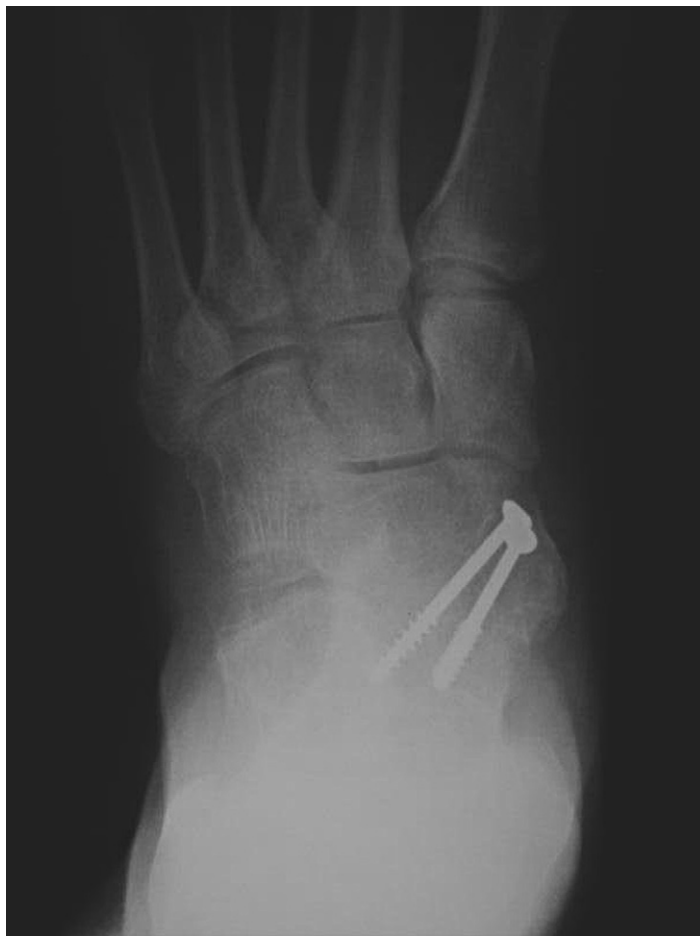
A 1-year postoperative anteroposterior radiograph following isolated talonavicular arthrodesis. Note the relocation of the talar head behind the body of the navicular and the overall decrease in the Kite's angle.
